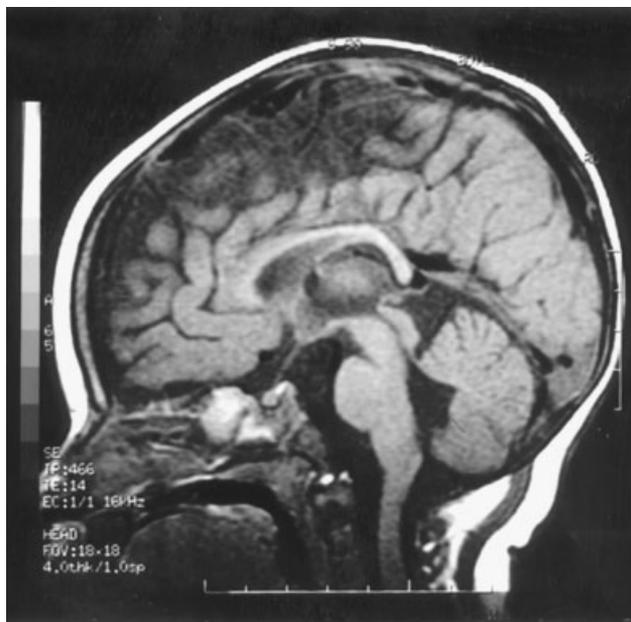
Sagittal view of probands cranial MRI showing hypoplastic corpus callosum and cingulate gyrus.
